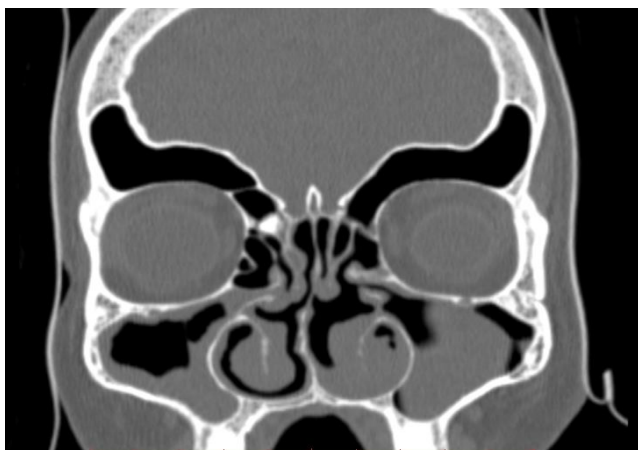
Coronal reconstructed CT of the paranasal sinus showing an osteoma at the left fronto-ethmoidal sinus junction. Left antral mucosal thickening and an isodense right antral lesion are noted.
